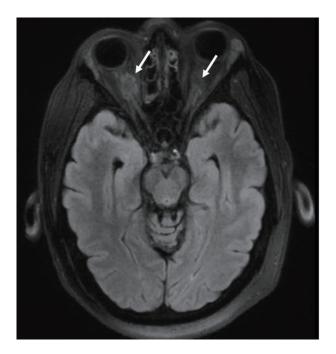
MRI of the brain demonstrated hyperdense lesions around the optic nerves, lesions appearing hypointense to the cerebral cortex on T2-weighted imaging, suggestive of Langerhans cell involvement.
